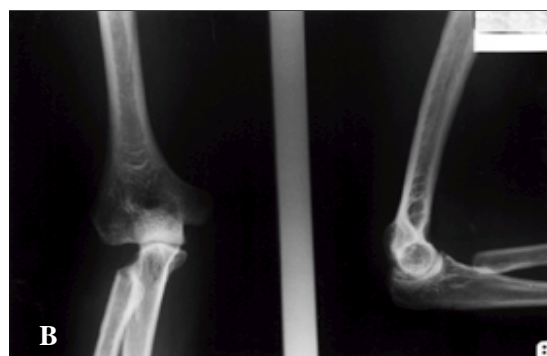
The radiographs of right elbow joint of 45 year old female patient show posterior dislocation of elbow joint with fracture of radial head and coronoid process
